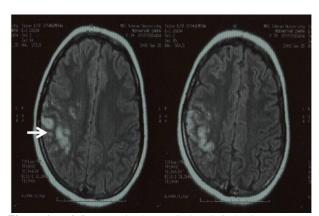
Left frontoparietal acute ischemia in brain MRI.
